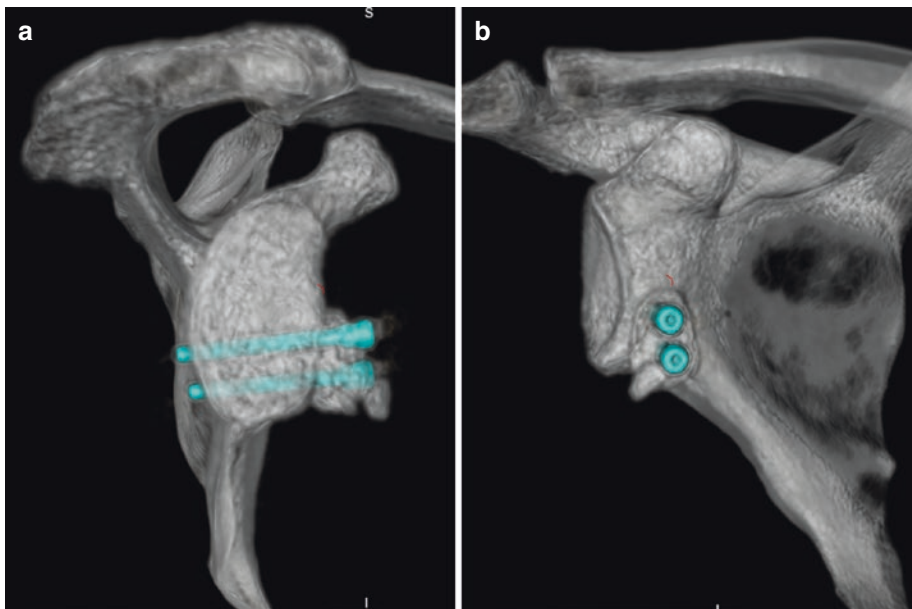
Arthroscopic Latarjet postoperative computed tomography (CT) scans with 3D reconstruction: (a) sagittal view and (b) coronal view
